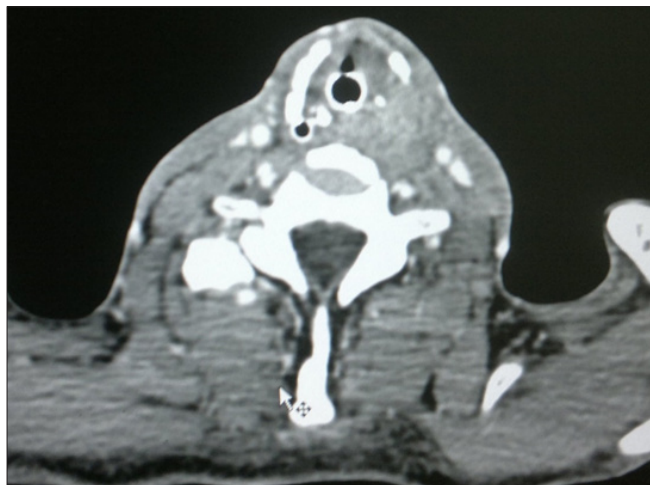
Computed Tomography Scan of Neck suggestive of Heterogeneously Enhancing Mass in the Left Lobe of Thyroid with Postero-lateral Displacement of Internal Jugular Vein and Carotid Artery with Compression of Oesophagus
